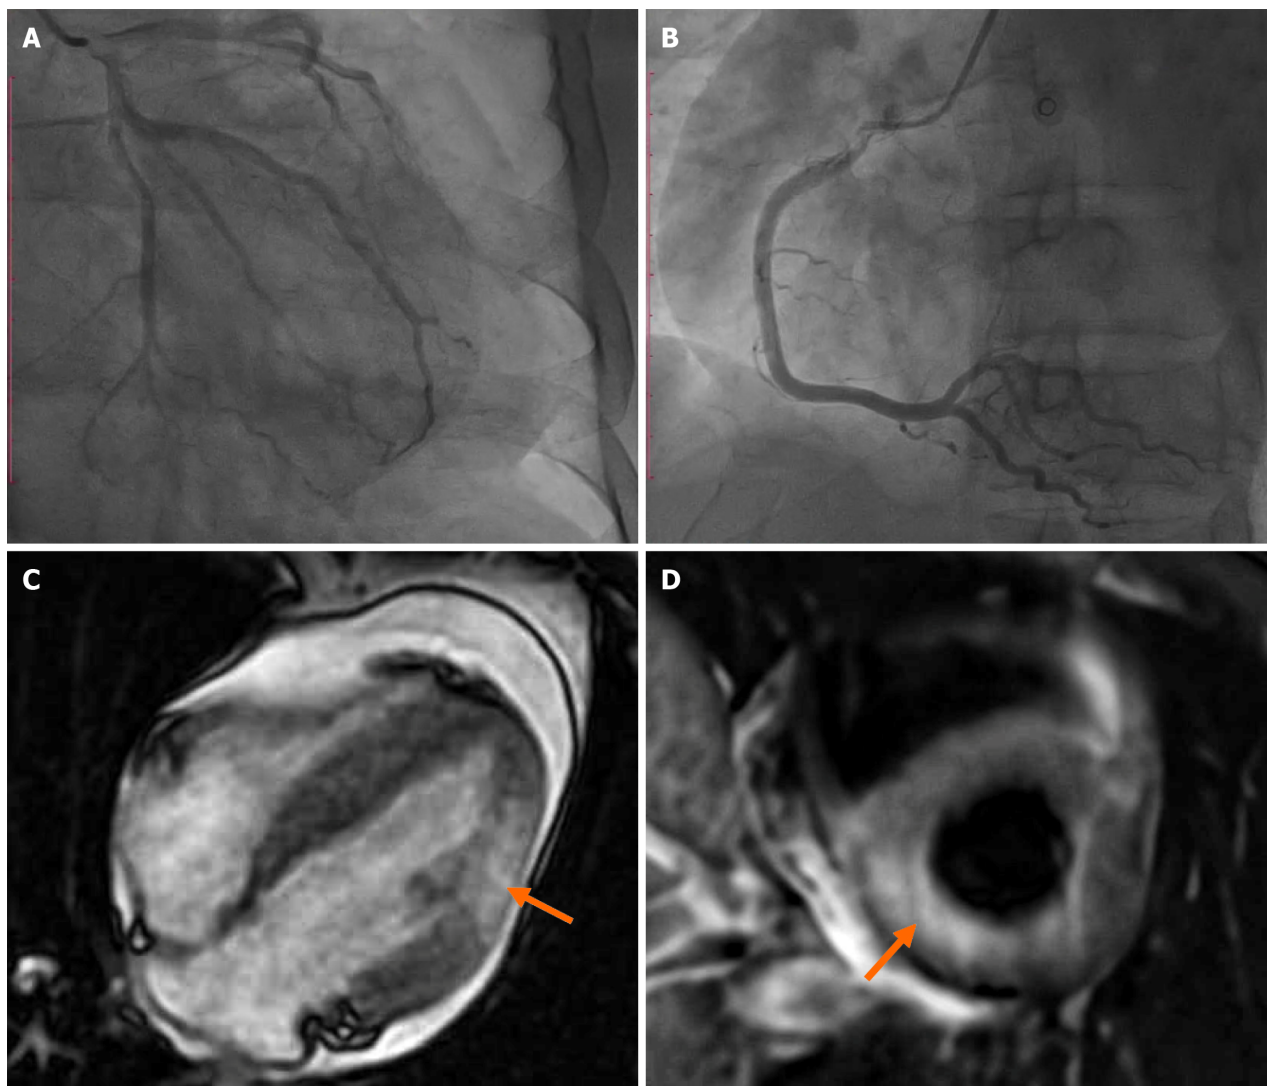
Coronary angiography and cardiac magnetic resonance imaging findings in a patient with suspected myocarditis. A and B: Coronary angiography reveals normal coronary anatomy with no evidence of luminal stenosis, effectively excluding obstructive coronary artery disease; C and D: Cardiac magnetic resonance imaging demonstrates focal myocardial injury indicated by arrows, characterized by increased signal intensity on T2-weighted imaging (edema) and late gadolinium enhancement in a subepicardial distribution of the lateral wall, consistent with acute myocarditis.
